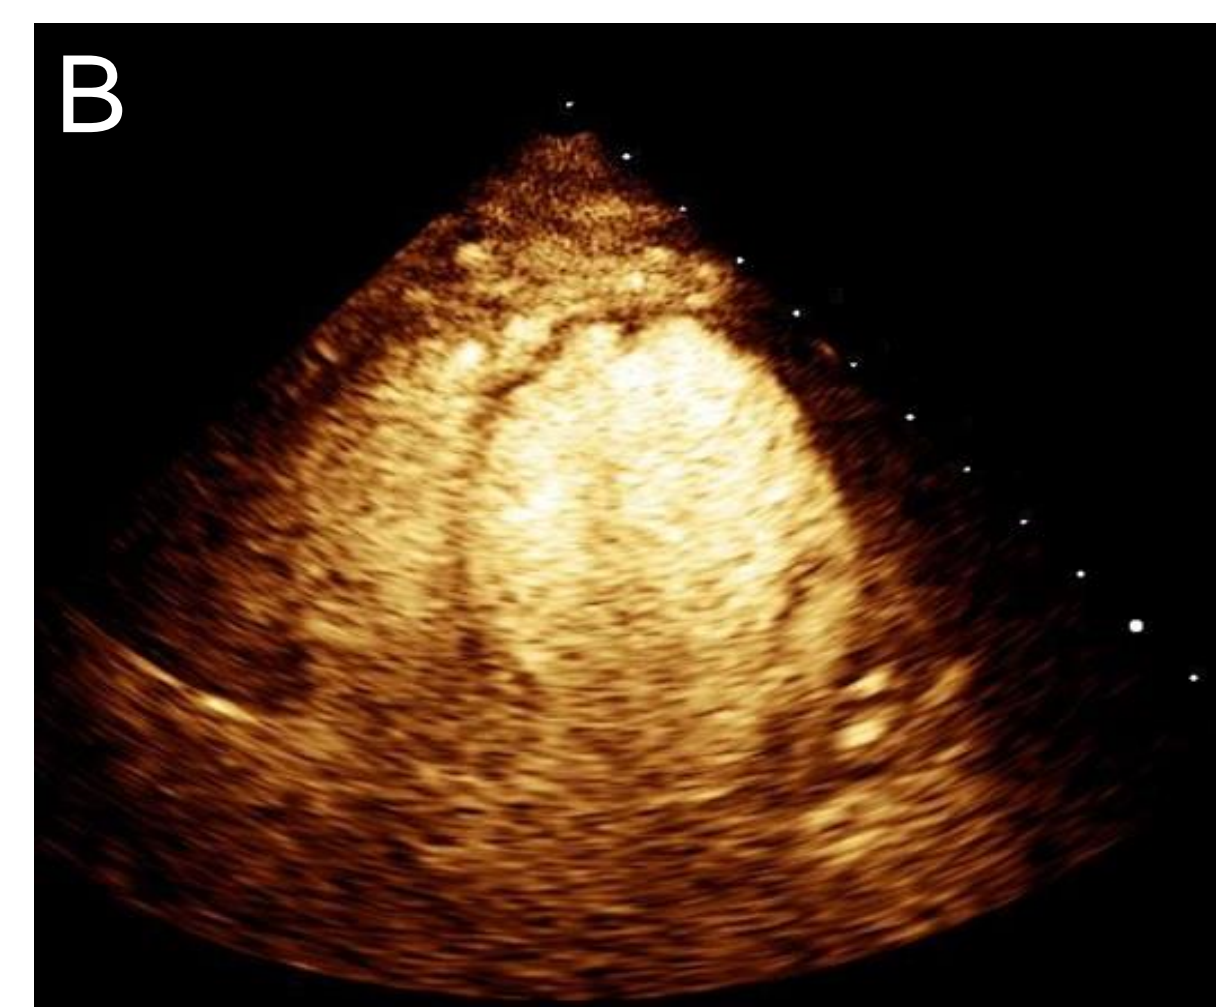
Echocardiogram. Representative images with anterior and apical ballooning and hypokinesis classic for Takotsubo cardiomyopathy.
